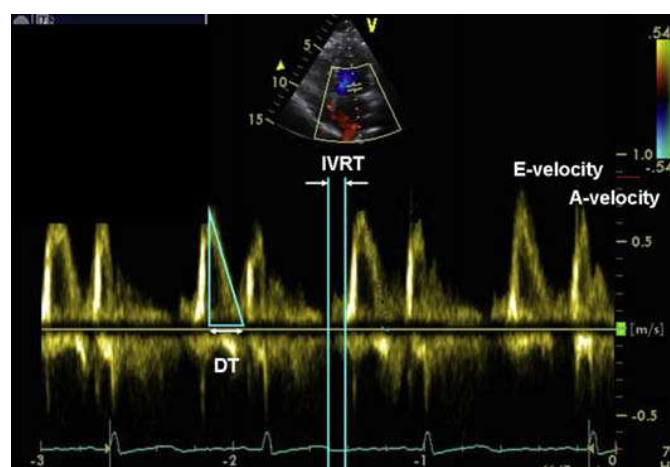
Mitral inflow velocities profile on pulse wave Doppler. A-velocity, atrial component of mitral filling; DT, deceleration time; E-velocity, IVRT, early diastolic mitral inflow velocity.(33)
